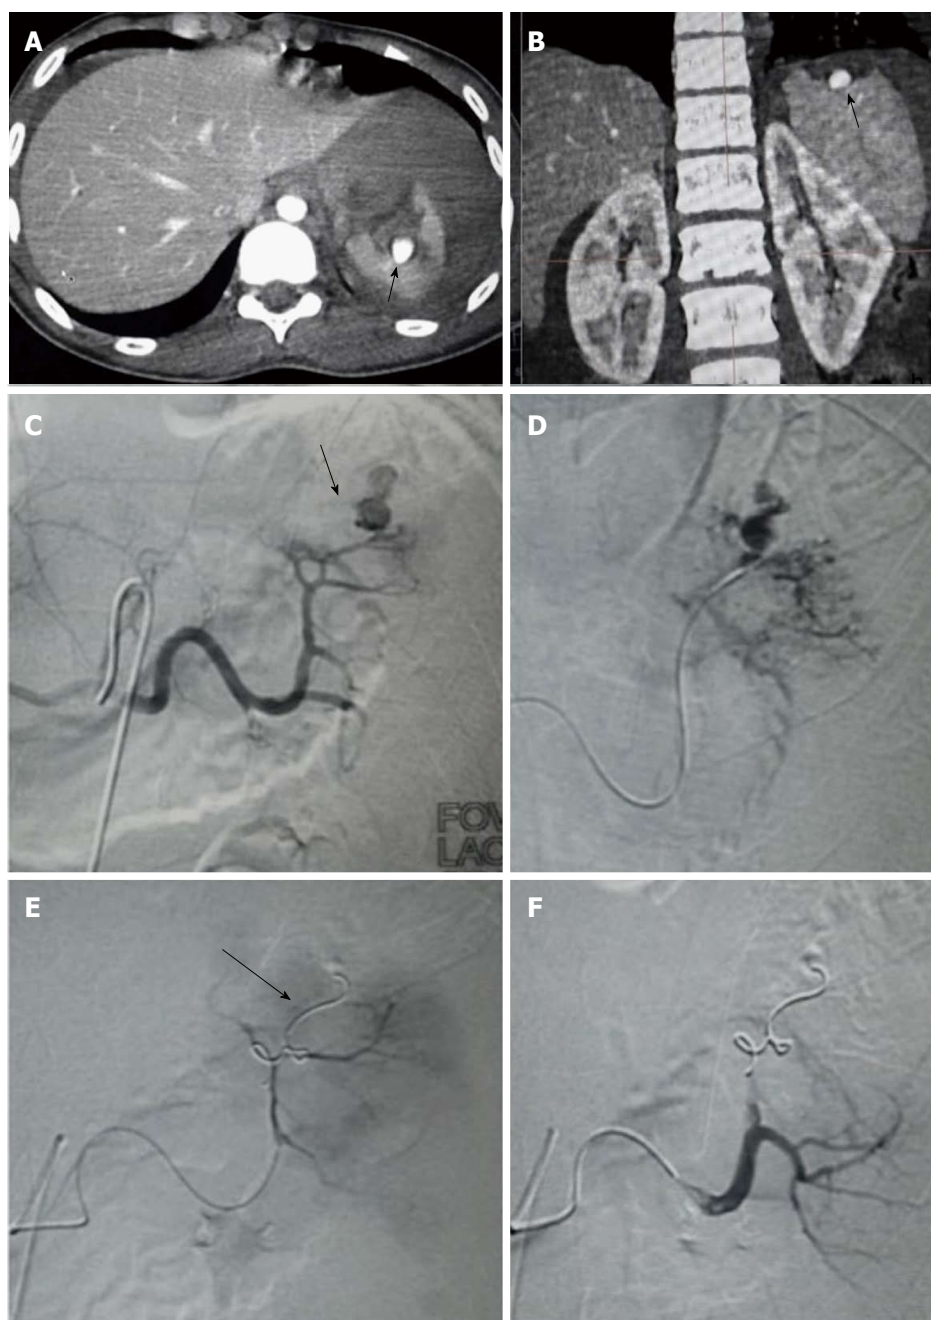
Splenic artery pseudoaneurysm. Case of 39-year-old female with BTA, FAST positive, hemodynamically stable. CECT revealed (A and B) Extensive lacerations involving spleen with presence of contrast filled intrasplenic outpouching paralleling the aortic attenuation s/o pseudoaneurysm. Splenic artery angiogram showed (C) PsA (arrow) arising from the upper polar branch which on delayed phases showed contrast spillage s/o leaking PsA (D). Subsequently, upper pole branch was selectively catheterised by microcatheter followed by deployment of microcoils (arrow) across the neck of PsA (distal embolization) (E). Post embolization angiography (F) showed no flow distal to coil with exclusion of PsA and good contrast opacification of lower pole branch. CECT: Contrast enhanced computed tomography; BTA: Blunt trauma abdomen; PsA: Pseudoaneurysm; FAST: Focused assessment with sonography in trauma.
